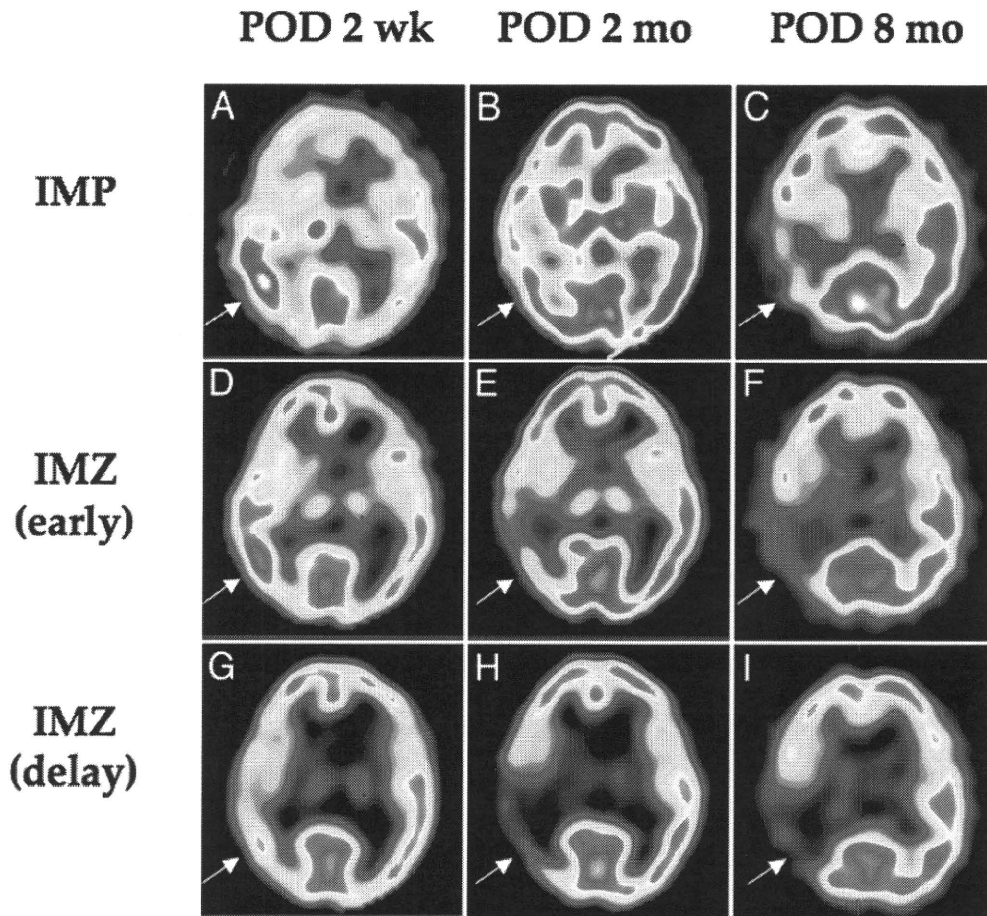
Chronological changes in <sup>123</sup>I-IMP and early and delayed <sup>123</sup>I-IMZ SPECT images. Iodine-123-labeled iodoamphetamine (A–C) and early <sup>123</sup>I-IMZ (D–F) images similarly showing a transient increase in the subacute stage (POD 2 weeks [POD 2 wk; A and D]), followed by progressive decrease in the early and late chronic stages (POD 2 months [POD 2 mo; B and E] and 8 months [POD 8 mo; C and F]) of uptake in the affected regions. Delayed images of <sup>123</sup>I-IMZ (G–I) demonstrating delayed decrease of binding of the affected regions between subacute (G) and early chronic (H) stages, which levels off in the late chronic stage (I). Arrows indicate the affected region in the temporal lobe.
